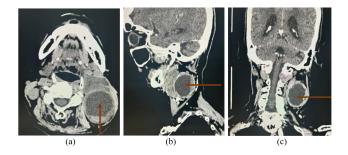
Computed tomography (CT) scan of the neck (a) Axial view, (b) and (c) sagittal section shows a mildly enhancing solid component with a posterior necrotic component, displacing adjacent structures, and a right lobe thyroid nodule
